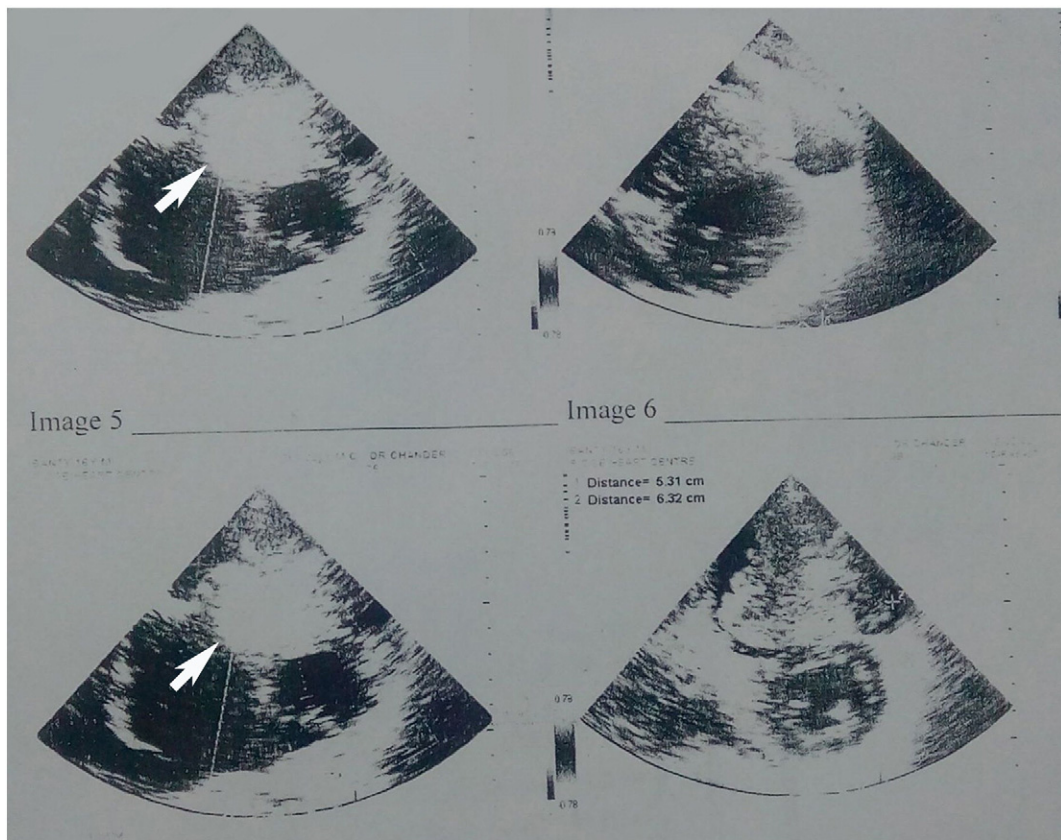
Transthoracic echocardiography images showing a large mass (white arrows) of uniform consistency, present in the right ventricle, prolapsing into the right atrium; the mass appeared to be attached to atrioventricular septum.
